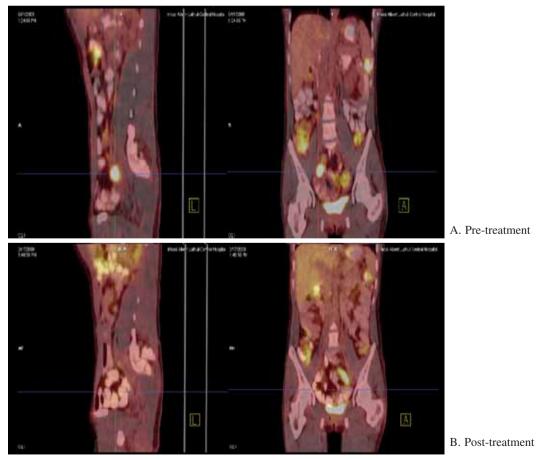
Comparison of FDG-PET scan images before and after treatment.
